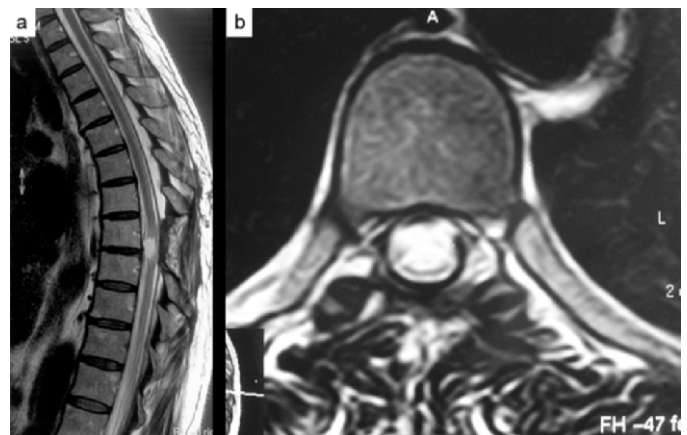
(a) Three-month postoperative dorsal MRI showing the spinal cord in an anatomical intradural location with reactive gliosis signal. (b) Axial MRI showing hyperintense parenchymal signal with reduced cord expansion.
